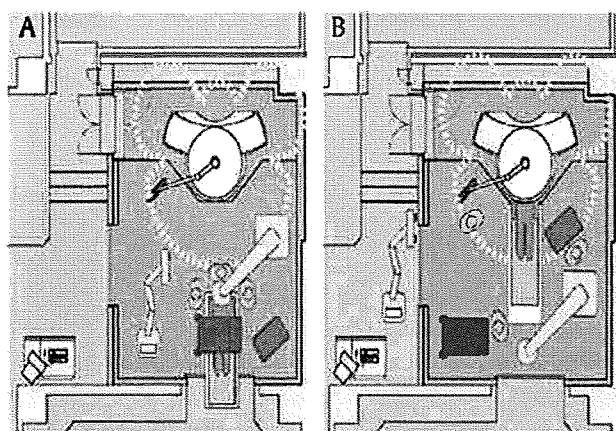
Scheme of the internal organization of the intelligent operating theater in the Tokyo Women's Medical University during a surgical procedure (A) and MRI scanning (B). The low magnetic field strength of the device (0.3 Tesla) provides narrow distribution of the 5-Gauss line (dotted line), which permits the surgeon to use some conventional surgical devices and instruments.
